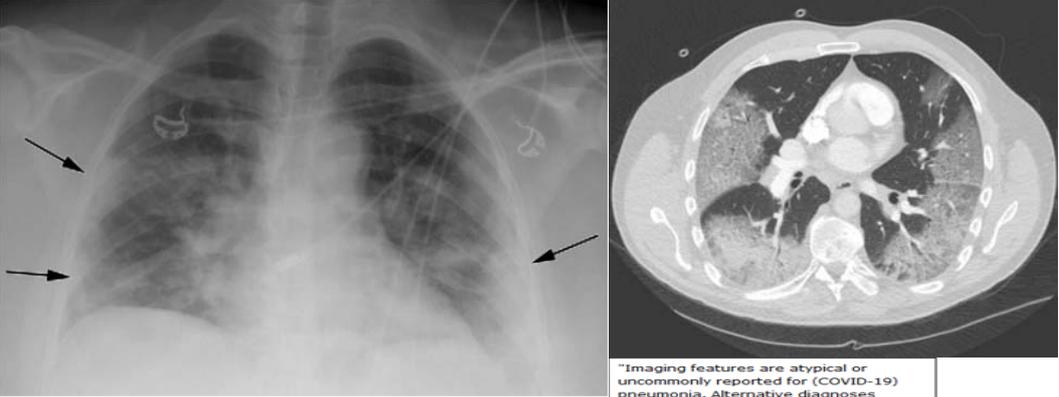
Characteristic chest radiograph in a 41-year-old woman presenting with cough and fever. Chest radiographic findings include bilateral patchy and confluent, bandlike ground-glass and consolidative opacity in a peripheral, mid to lower lung zone distribution (arrows).
